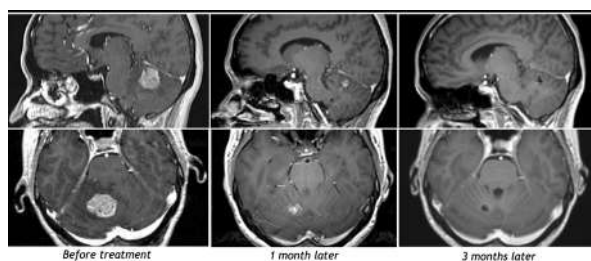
Serial MRI brain (T1WI with gadolinium) showing the result of GK SRS on the right cerebellar metastasis. There was total resolution of the lesion at 3 months post treatment.
